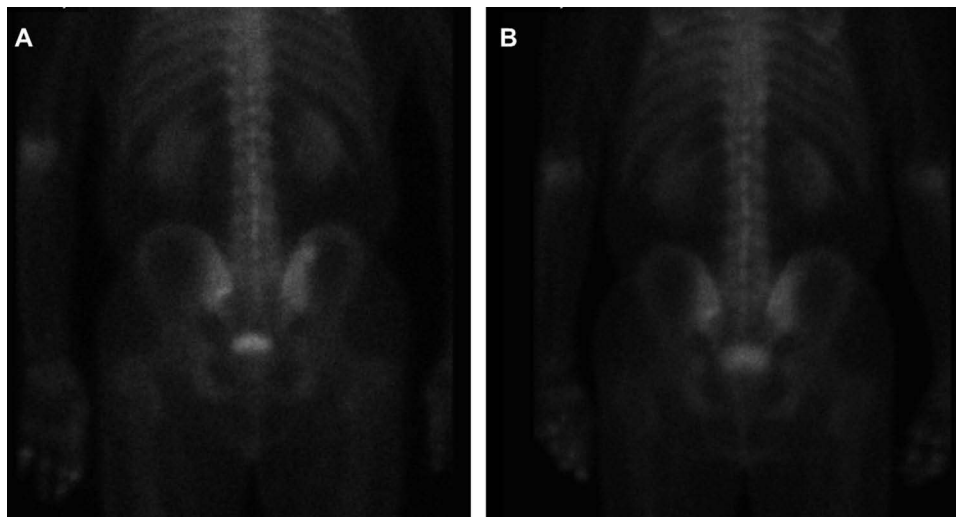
Bone scintigraphy (A) Baseline bone scans showing osteoblastic lesions at the pelvis. (B) Bone scans performed 3 months after SL-28 therapy showing no metabolic activity in the pelvis compared with the baseline bone scan (A).
